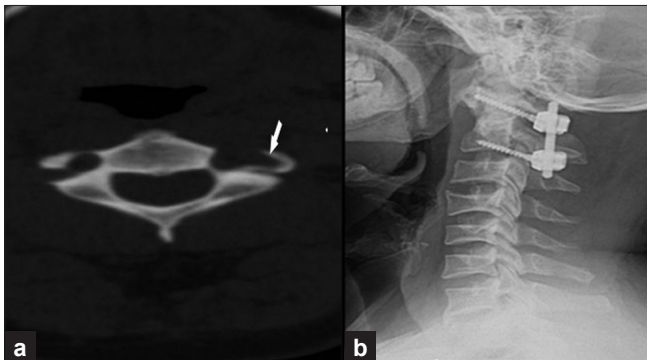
(a) Preoperative CT scan (axial cut) evaluation of patient (case IV) with abnormally large foramen transversarium at C2 with inadequate bone for screw placement; (b) cervical X-ray showing 1-year follow-up with adequate fusion in a well-reduced fixation achieved with unilateral fixation
